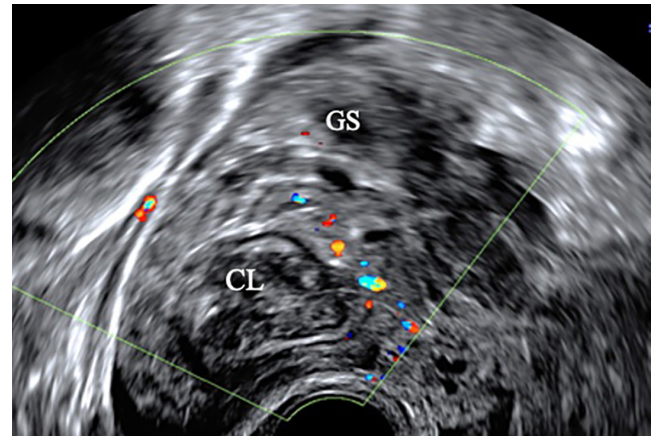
Transvaginal ultrasound image with color Doppler in transverse view of false-negative ovarian ectopic pregnancy that was described as tubal ectopic pregnancy. Corpus luteum (CL) is seen within ovary and gestational sac (GS) appeared to be adjacent to ovary. At surgery, this was confirmed to be an ovarian ectopic pregnancy.
